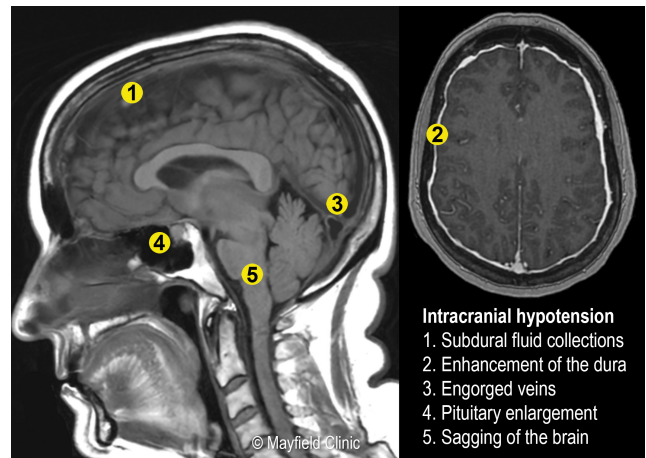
MRI scans of brain sag (left) and enhancement of the dura (right; white edges around brain).
